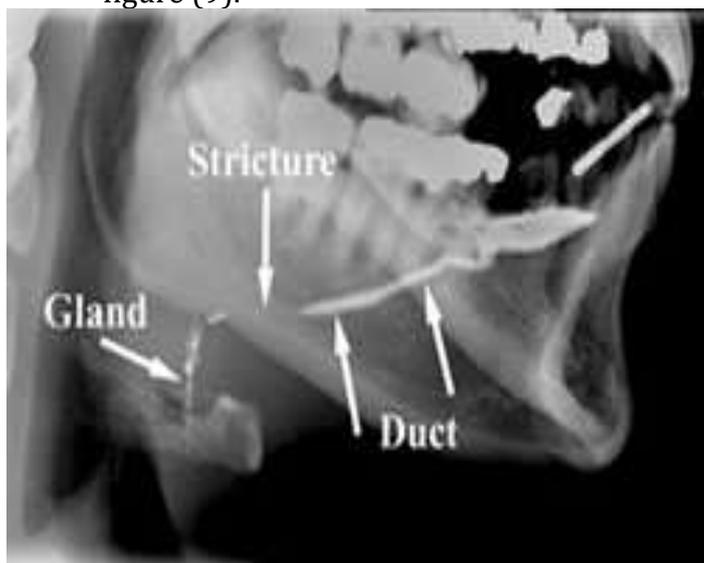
shows the imaging section for salivary glands by using Sialogram technique X-ray (UR Medicine Imaging Specialties, Sialogram, 2022)
